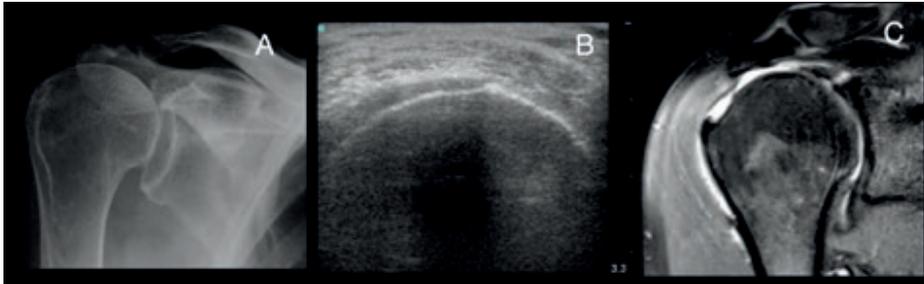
(A) Radiograph of MRCT with cranial displacement of the humeral head; (B) Bald head on ultrasound scan; (C) MRI scan showing retracted massive tear with cranially displaced humeral head and muscle wasting
